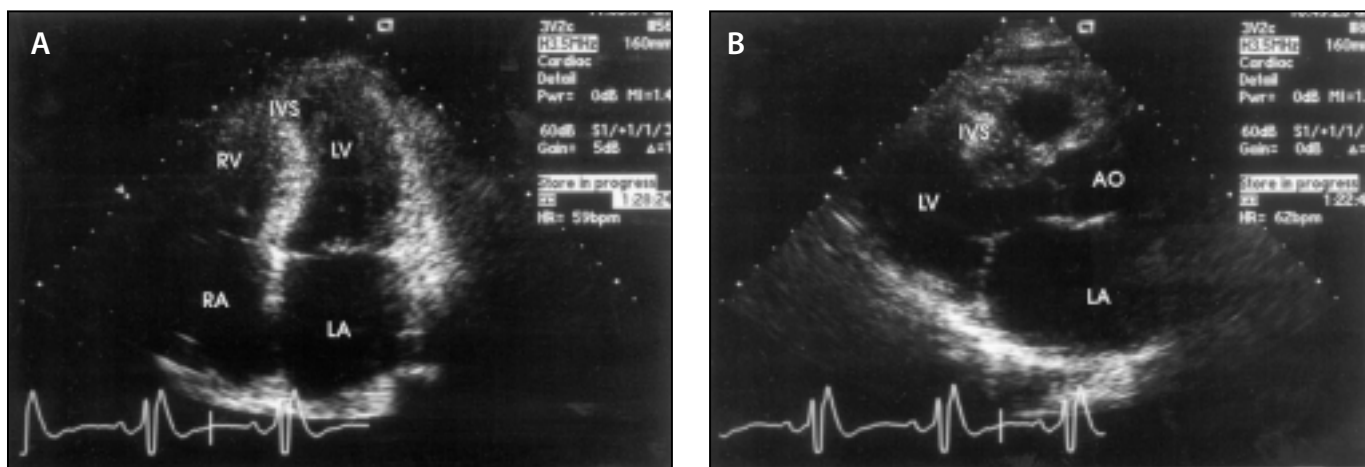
Echocardiograms demonstrating interventricular septal and posterior wall thicknesses of 30 mm and 14 mm, consistent with asymmetric septal hypertrophy. Left ventricular end-diastolic and end-systolic dimensions were 39 and 30 mm, respectively. (A) parasternal, long axis view; (B) apical, four chamber view.
